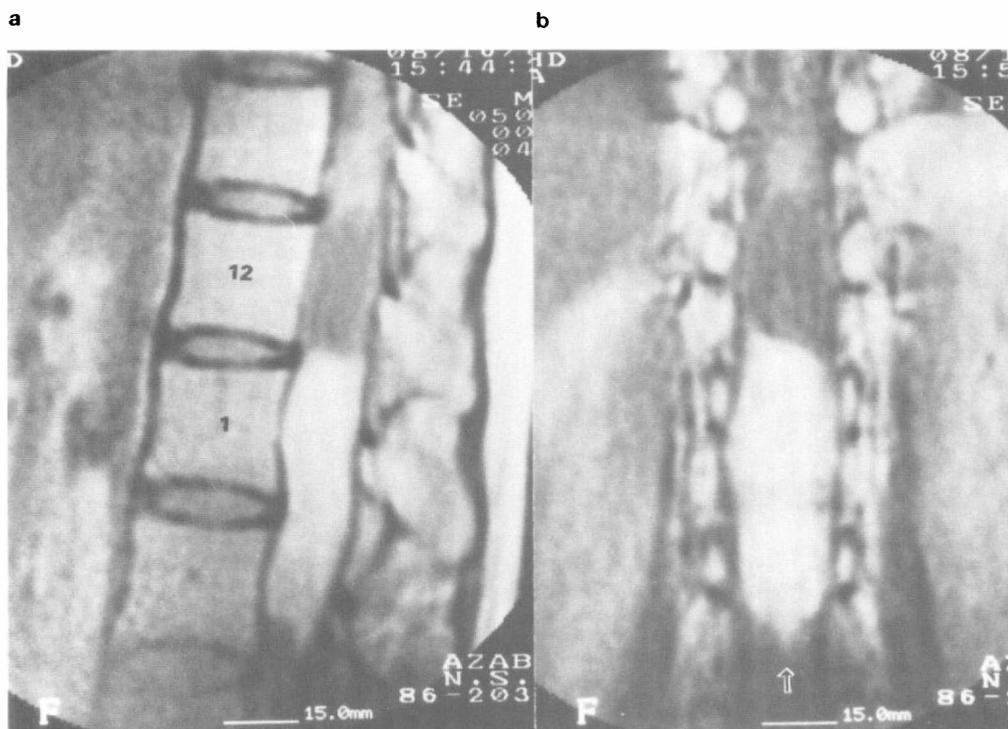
Case 3, endependymoma. T1-weighted MR images with Gd-DTPA enhancement showing the massive part of the tumour at the L1-2 level and the cystic part above it. (a) is sagittal and (b) is a coronal view. Note that the caudal end of the exophytic enlargement of the tumour is extending caudally in the midlongitudinal direction (arrow).
